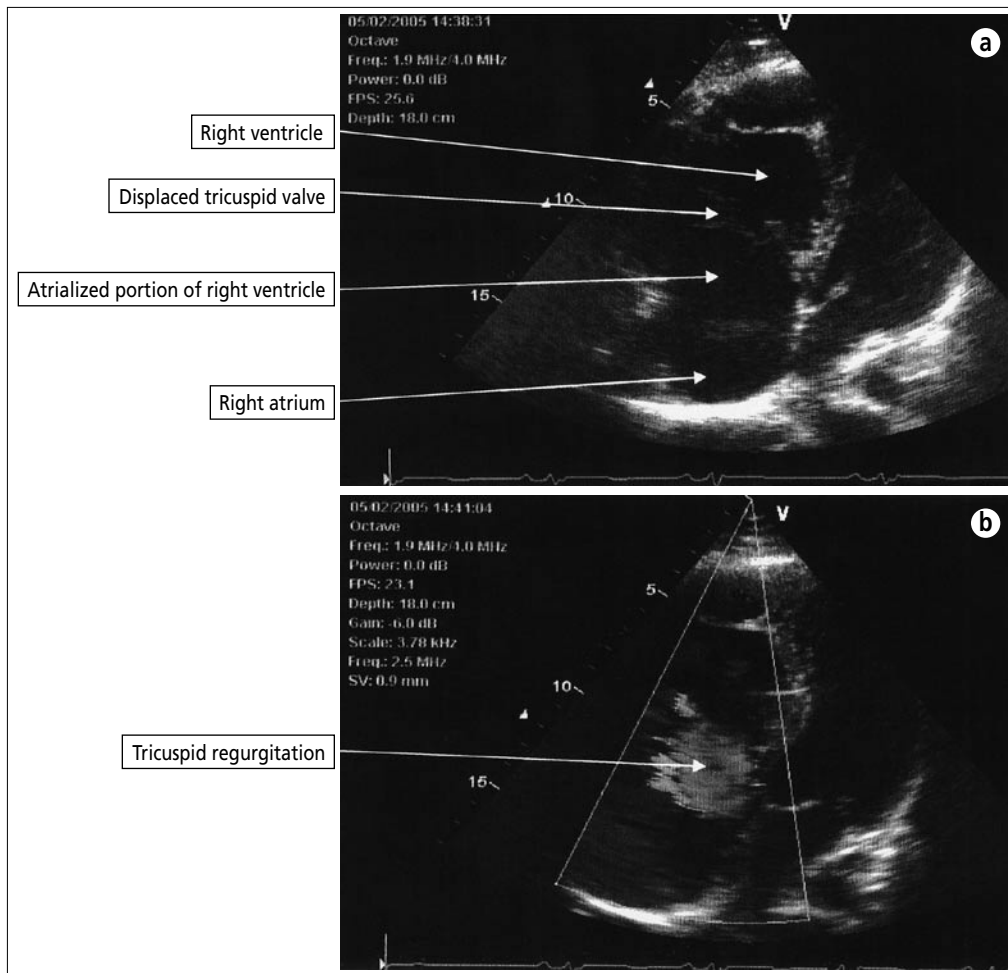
Apical 4-chamber echocardiographic views showing (a) the apically displaced tricuspid valve and the atrialized portion of the right ventricle and (b) tricuspid regurgitation on the color Doppler study. Despite the apical displacement of the tricuspid valve, the functional right ventricle is of adequate size, which probably explains the patient's lack of cardiac symptoms.
